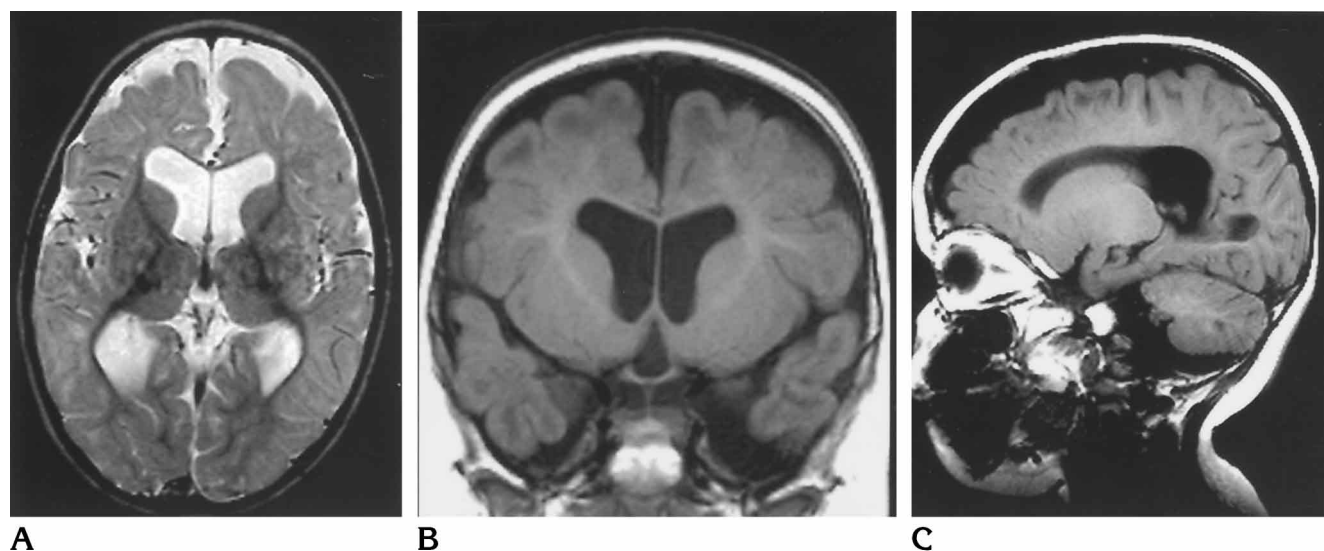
MR imaging in same child at the age of 22 months, after 1 year of therapy with betaine monohydrate. A, Turbo IR image (6000/19; inversion time, 250) shows less atrophy than in Fig 1A. The size of the ventricles has increased slightly, while the areas of delayed myelination in the frontal regions have decreased. Coronal (B) and sagittal (C) T1-weighted images (660/15) show a decrease in the size of the hypointense regions, indicating progressing myelination.
